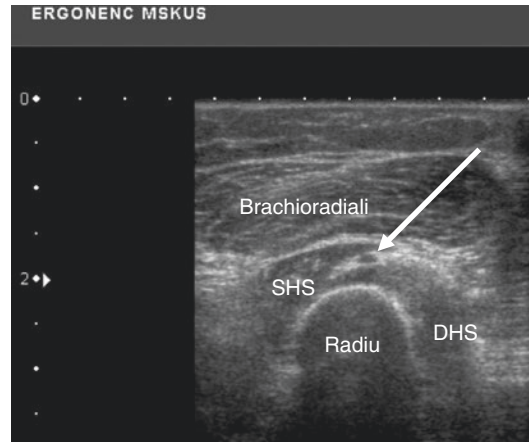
Sonogram of the deep branch of the radial nerve (white arrow), PIN injection with a short-axis in-plane approach. Deep head of supinator (DHS). Superficial head of supinator (SHS)
